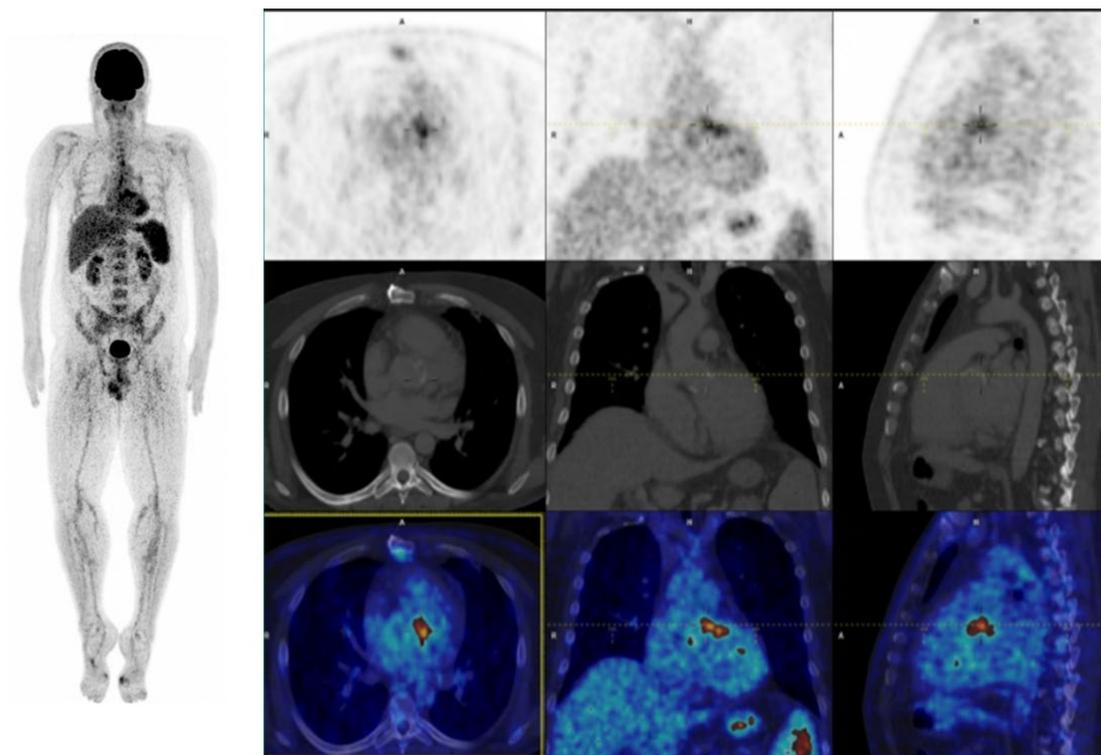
18F-FDG PET-CT scan of a 46 years old man biological prosthetic aortic valve endocarditis (labcor 25) showing glycolytic hypermetabolism in prosthetic aortic valve that points to infection.
